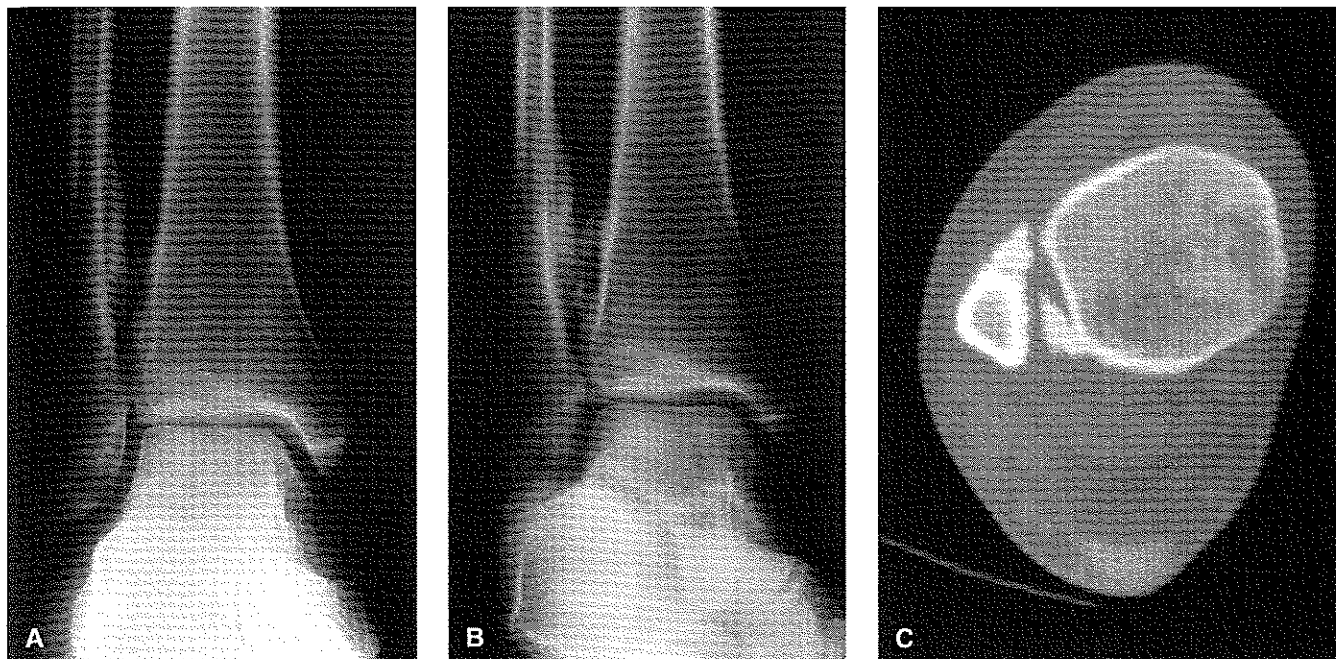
Mortise (A) and internal oblique (B) radiographs and a computed tomography image (C) in a patient 18 months after a supination external rotation ankle fracture. Extensive calcification within the interosseous membrane, fibular shortening, and chronic tibiofibular diastasis are evident.
